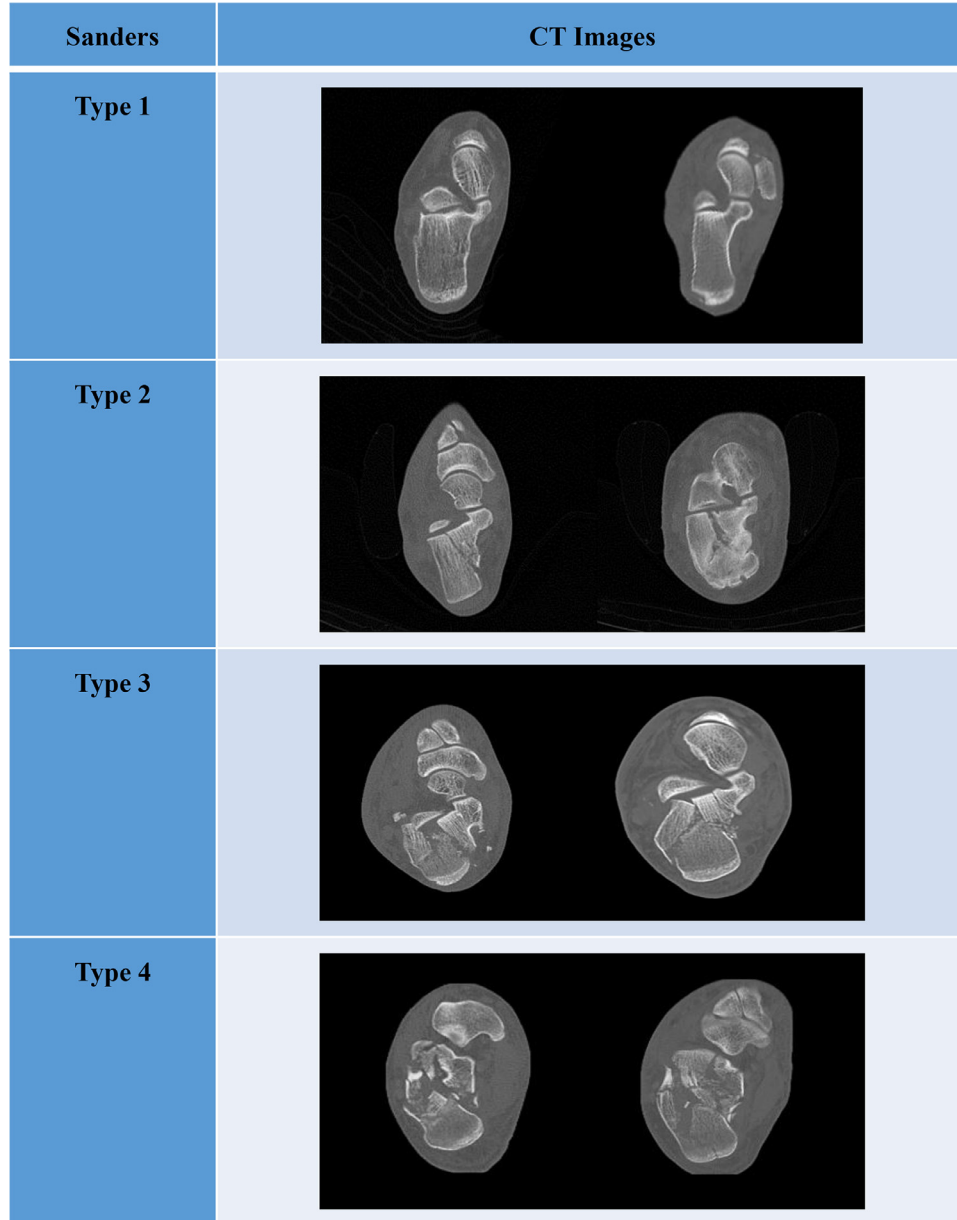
Examples CT scan images of calcaneal fracture of Type 1–4 of Sanders classification system. Type 1 includes all intraarticular fractures that have less than 2 mm of articular displacement. Type 2: displaced with one fracture line in the posterior facet. Type 3: displaced with two fracture lines in the posterior facet. Type 4: comminuted with more than three fracture lines in the posterior facet.
